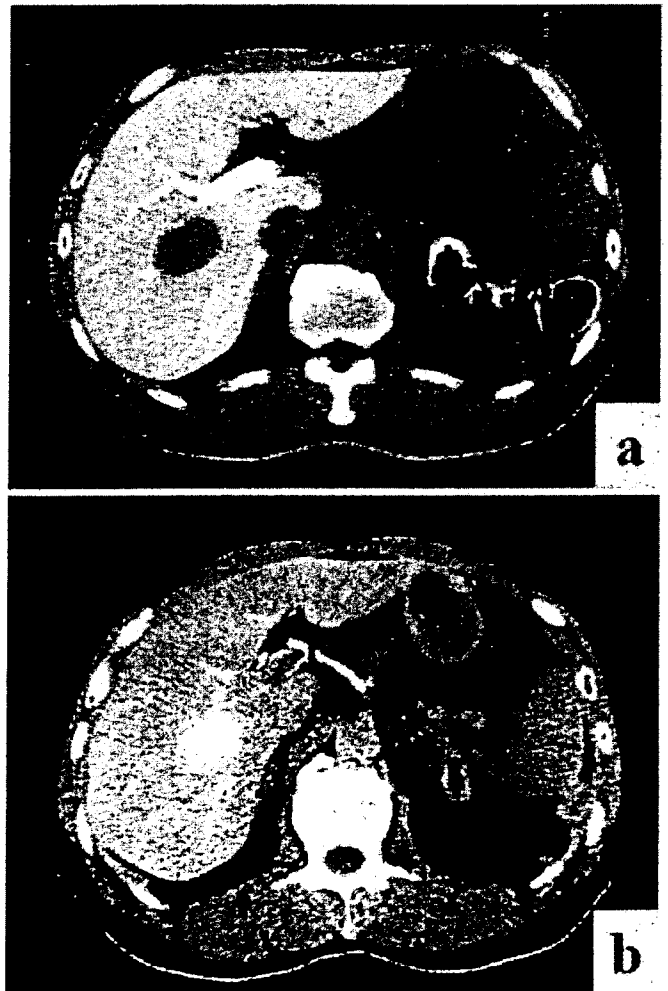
Abdominal CT. A perfusion defect in the S6 region of the liver is shown by the portography (a). This tumor was shown to be hypervascular by arterial angiography (b).
